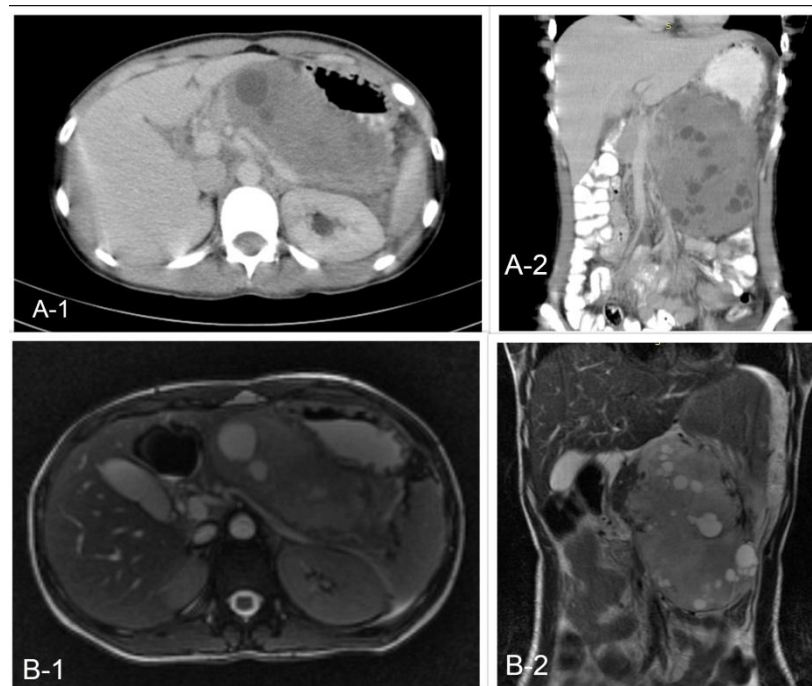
A-1, A-2 are CT images and B-1, B-2 are MRI images showing the solid lesion with cystic areas arising from body of pancreas abutting posterior stomach wall.
